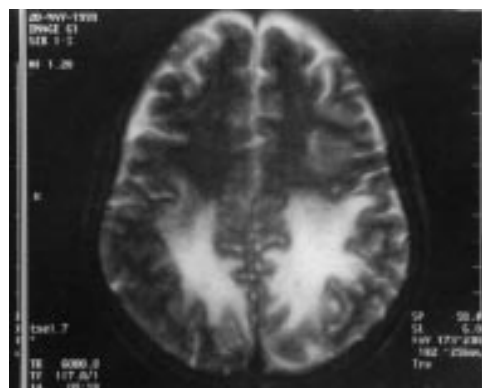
T2 weighted magnetic resonance image showing white matter signal abnormalities in parieto-occipital regions.
